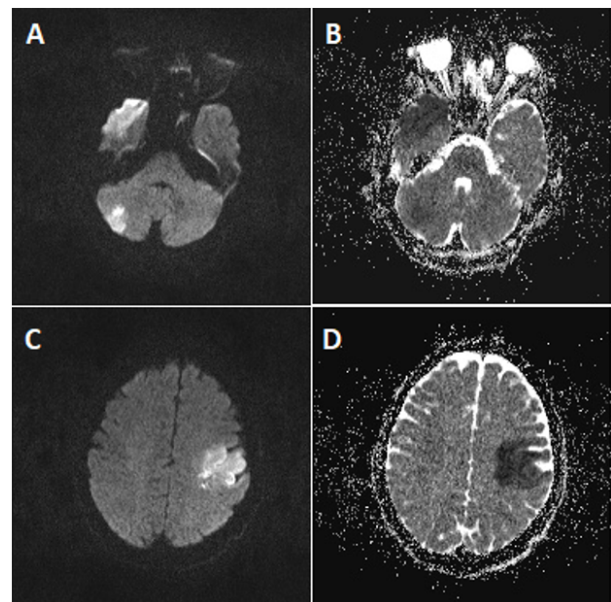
Diffusion weighted magnetic resonance imaging (B value = 1000) shows high signal lesions in right temporal lobe, left parietal lobe, and both cerebellar hemispheres (A and C). The apparent diffusion coefficient (ADC) maps show low signal lesions in these areas suggesting restriction and cytotoxic edema (B and D)
